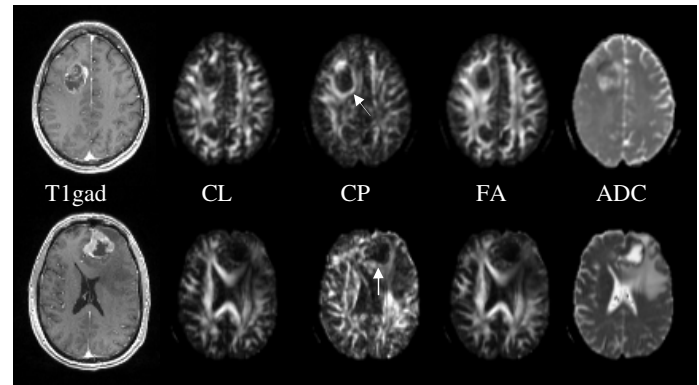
MR images of patients with glioblastoma (upper row) and brain metastasis (lower row) showing ring enhancement. Higher CL, CP and FA from the enhancing part in glioblastoma were noted compared to metastasis. Note the capsule-like ring on CP maps of both glioblastoma and metastasis patients (arrows).
